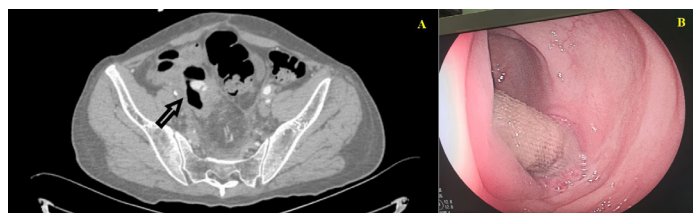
A. Abdominal CT angiography revealed a suspicious vascular structure in the colon segment on the right side (arrow); B. Colonoscopic view of the aorto-bifemoral graft inside the sigmoid colon
